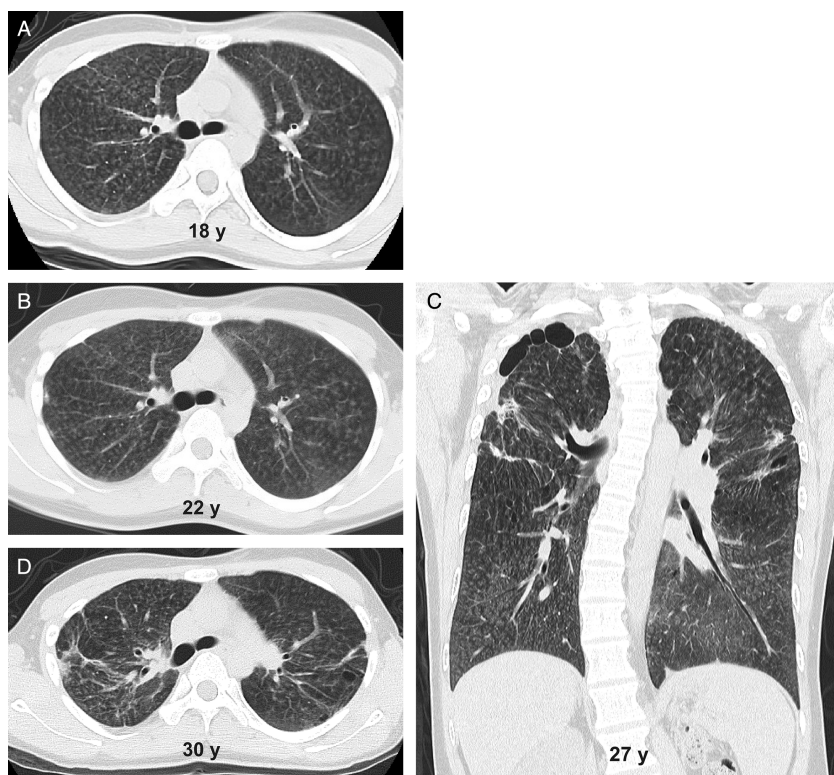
Longitudinal course of computed tomography (CT) images of the chest. (A) CT showed diffuse centrilobular ground-glass opacities at 18 years; (B) at 22 years; (C) at 27 years, fibrotic changes in both upper lobes were recognized; and (D) at 30 years, the fibrosis changes deteriorated.
